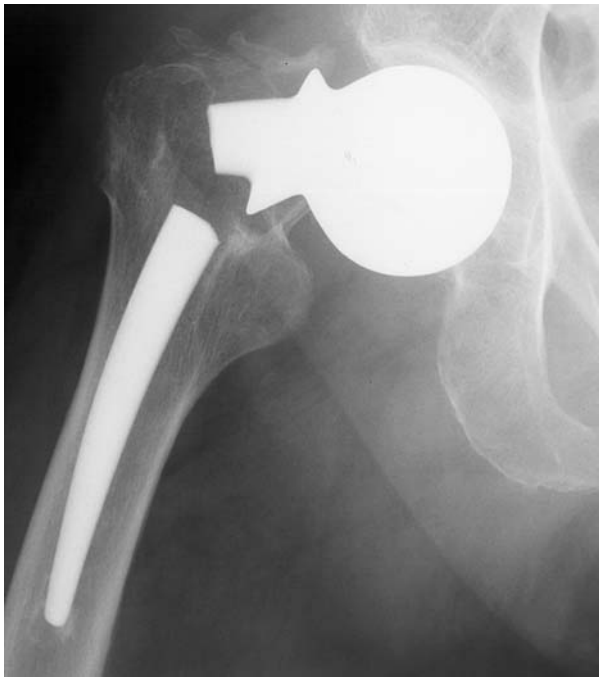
Radiograph of the hip with the broken stem
